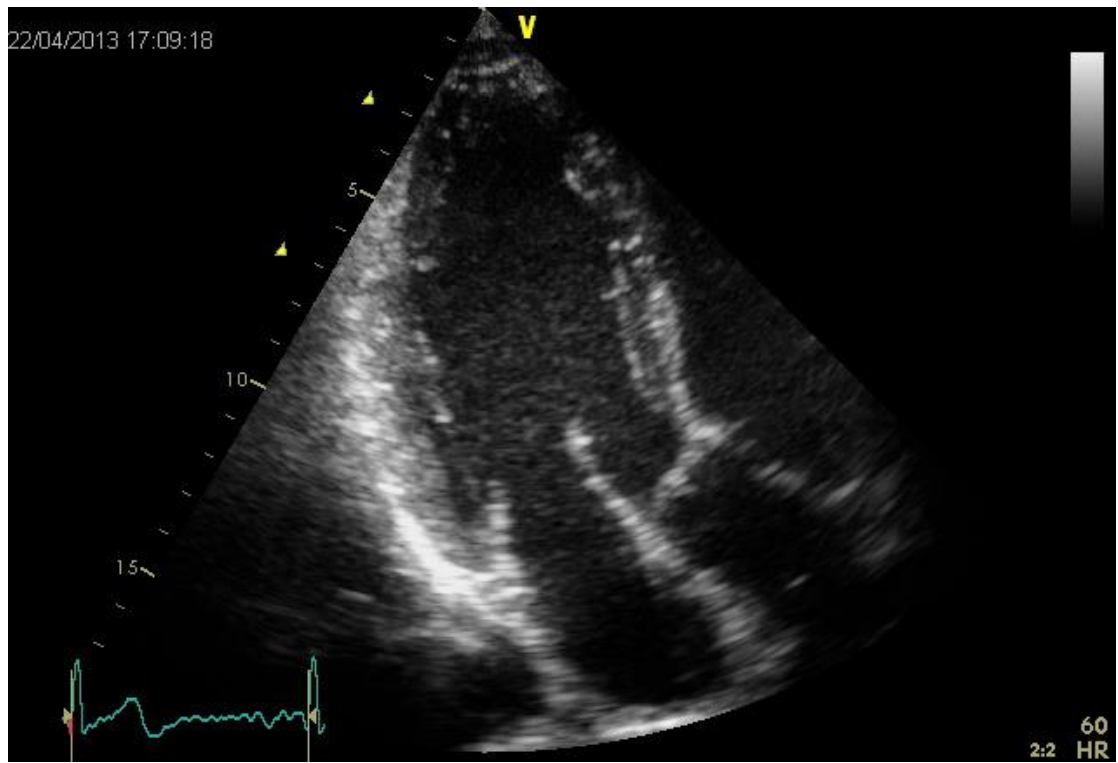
Apical Three Chamber View.
